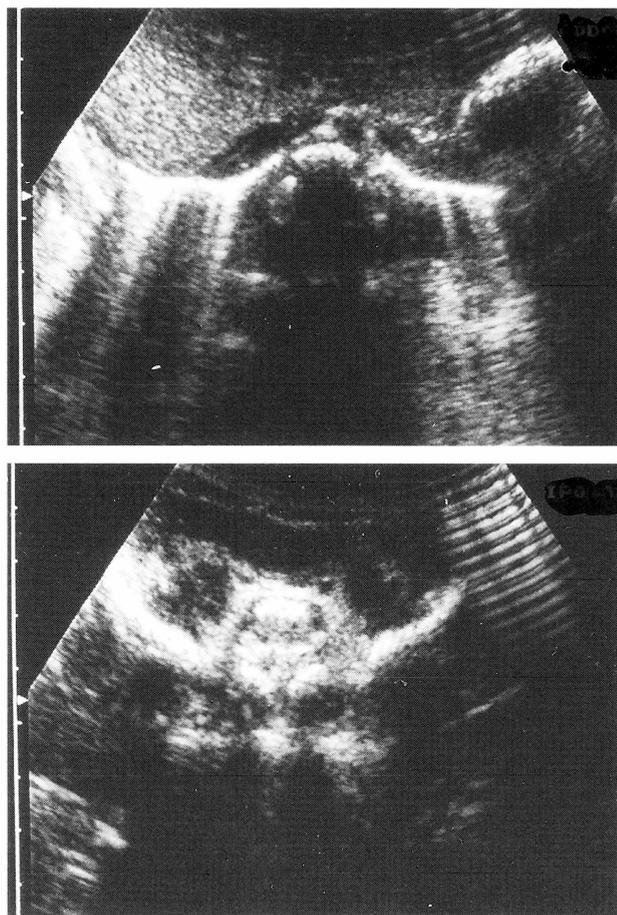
Ultrasound shows the absence of both kidneys (a) and the absence of the bladder in front of the rectum (b).
